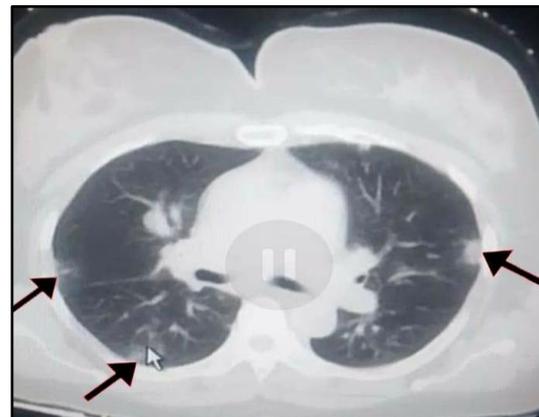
Spiral lung CT scans revealed ground-glass opacity in the lung.
